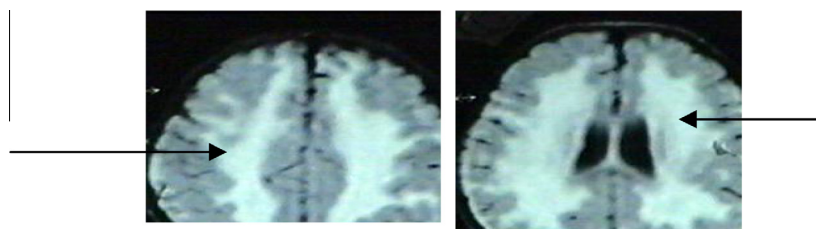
Flair Brain MRI of Case 1 showing bilateral diffuse cerebral demyelination in the deep periventricular white matter (left) and in centrum semiovale (right) (Arrows).
